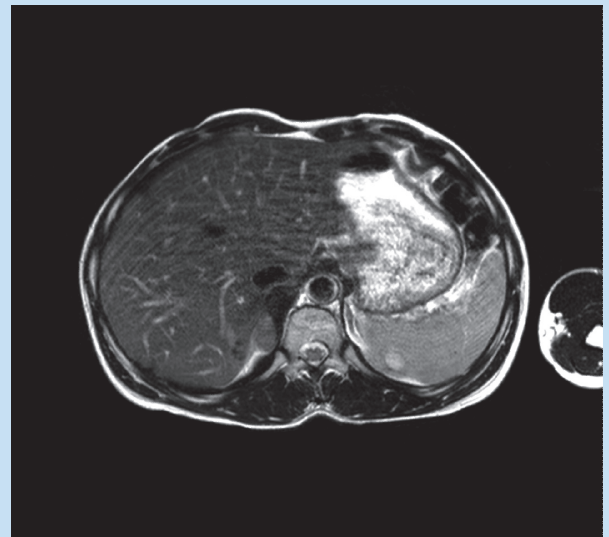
Axial T2 (TR 2.01/TE 100) weighted MRI sequence demonstrates a right adrenal mass which has higher signal compared with the liver but lower signal compared with surrounding fat.
